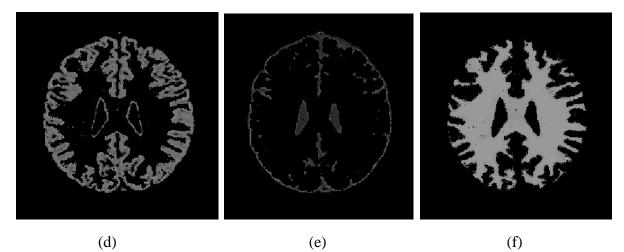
(a) Normal Brain(T1-weighted slice 100), (b) Normal brain (noise 5%), (c) Segmented result using ACO-FCM, (d) Gray matter, (e) CSF, (f) White matter
